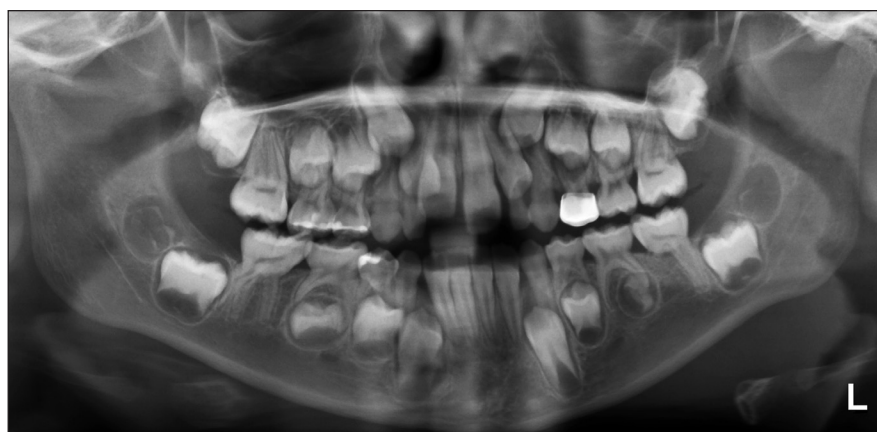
Case one panoramic radiograph. Note the cervical constriction and abnormal root morphology of the permanent mandibular first molars as well as the thin roots and constriction of pulp chambers on the permanent maxillary first molars, which is consistent with molar-incisor malformation.
